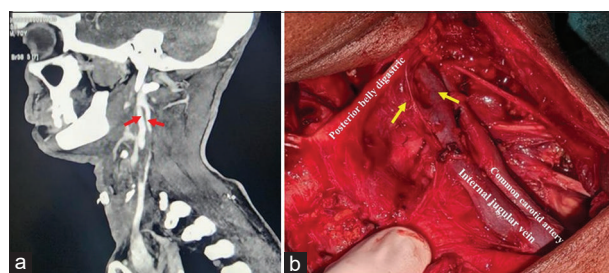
(a) Computed tomography angiography image showing fenestrated internal jugular vein (red arrows); (b) Fenestration of internal jugular vein (yellow arrows) found intraoperatively during neck dissection
